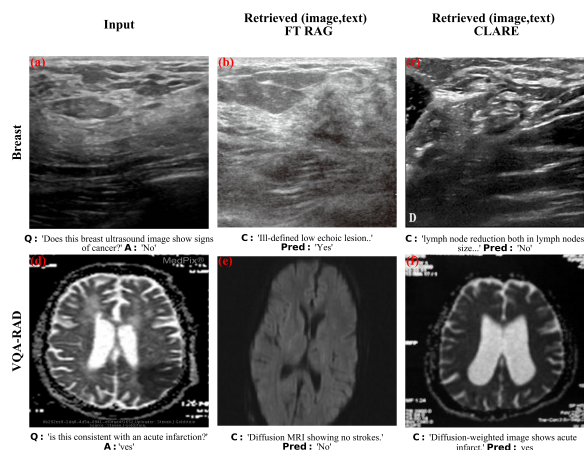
LVLMM-aware multimodal retrieval finetuning impacts inconsistent retrieval predictions. After LVLMM-aware multimodal retrieval finetuning, retrieved images show greater alignment with query image labels. In Breast, a cancer-free ultrasound query (a) initially retrieved a lesion image (b), however, after finetuning, the retrieved image is less directly related to the wrong label (c). In VQA-RAD, retrieval shifted from an unrelated medical condition (e) to an image depicting the condition of the query image.
